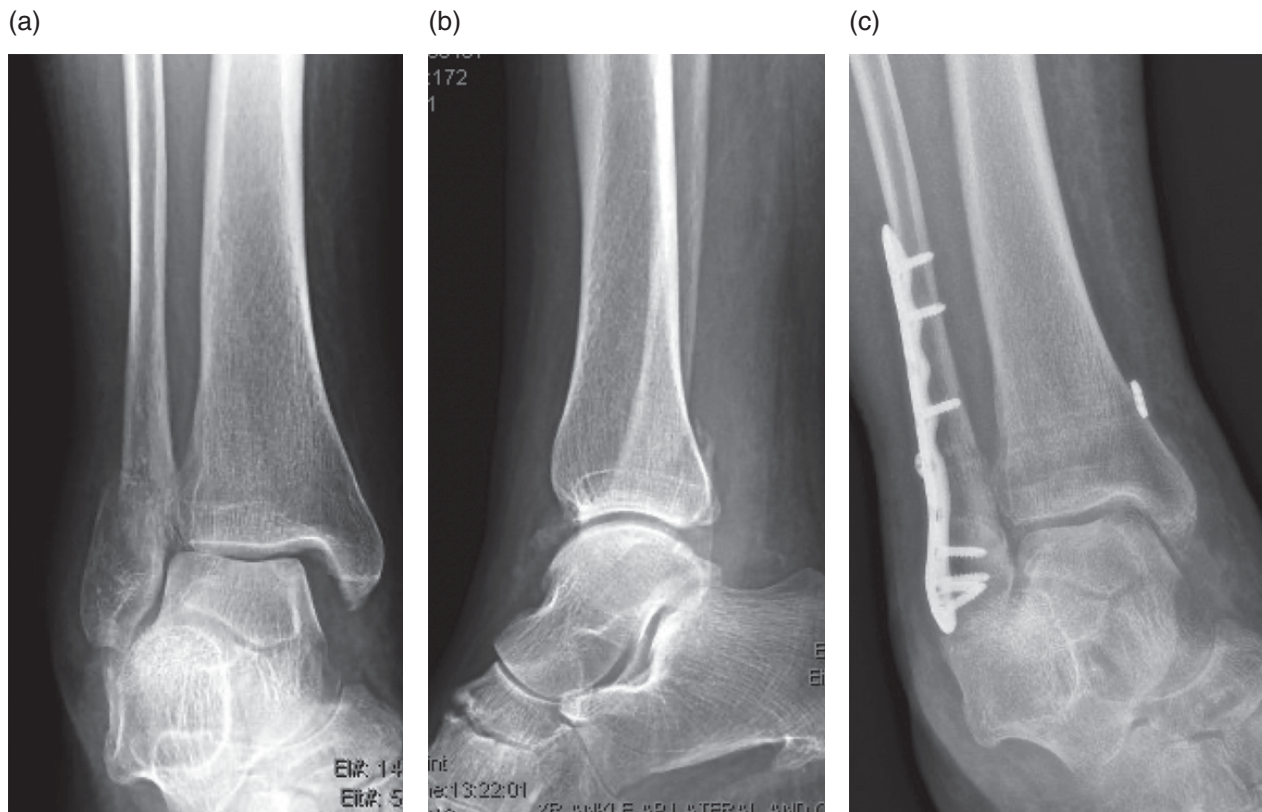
A mortise (a) and lateral (b) radiograph of a 67-year-old female who sustained an unstable ankle fracture after a twist and fall down the stairs. Medial clear space widening of the ankle mortise indicated medial ankle instability. She underwent an open reduction internal fixation of the distal fibula with a locking plate, as well as syndesmosis fixation with a suture-button device to stabilize the ankle mortise (c). The mortise is symmetrically reduced in the postoperative radiograph.
